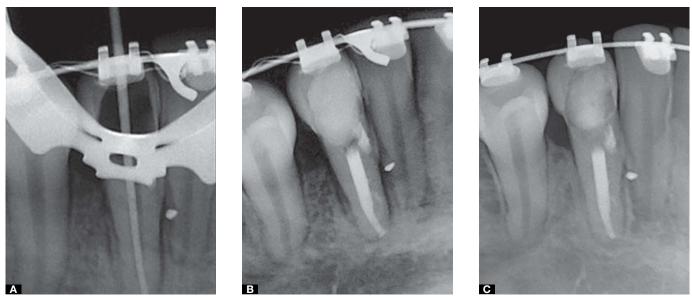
A) Master cone and presence of accessory mesial canal. B) Final radiograph. C) 10-month follow up.
